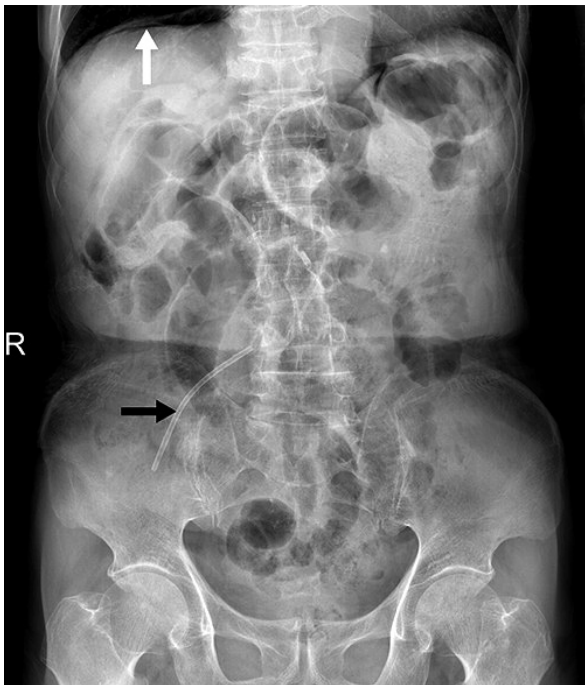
Plain abdominal X-ray shows subphrenic free air (white arrow) over right upper quadrant of abdomen and ERBD stent over right lower quadrant of abdomen (black arrow).
